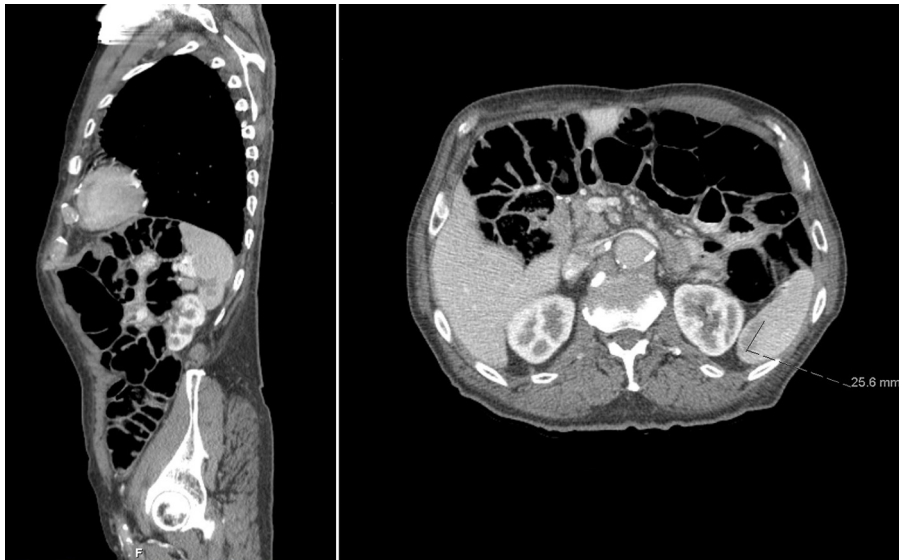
Image of CT scan showing a 25 mm splenic lesion, near its inferior pole, compatible with metastasis.
